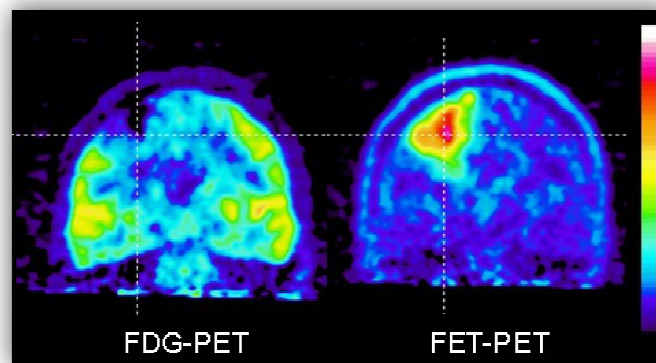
Anaplastic astrocytoma grade III studied by PET/CT with two different tracers: FDG, on the left, and ^{18}F -Fluoro-Ethyl-Tyrosine (FET) on the right. FET PET allows a precise definition of the cancerous tissue (47).
